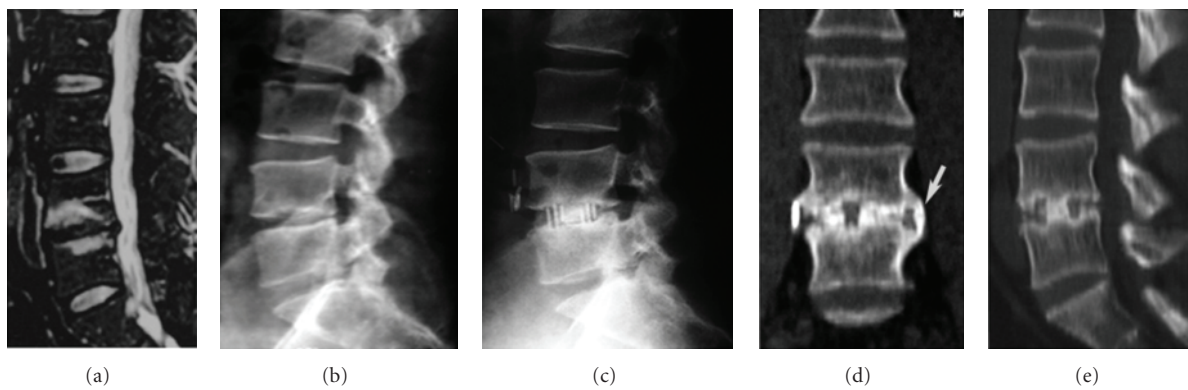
Case example number 1. Male, 54 years old, 7-year pain history which used to get worst by end of the day, refractory to physiotherapy and chiropractic. VAS scores-preoperative 8; 1-week 2; 24-month 1. Patient underwent an L4L5 stand-alone lateral interbody fusion. (a) Preoperative sagittal MRI. (b) Preoperative lateral orthostatic X-ray. (c) 24-month lateral orthostatic X-ray. (d) 24-month computed tomography coronal reconstruction, arrow shows fusion sentinel sign. (e) 24-month computed tomography sagittal reconstruction.
